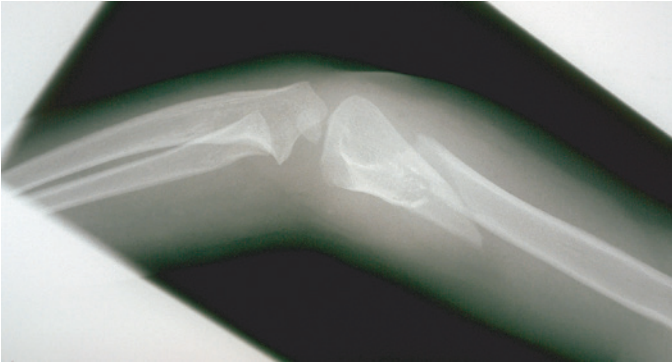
■ X-ray of an oblique fracture of the femur
